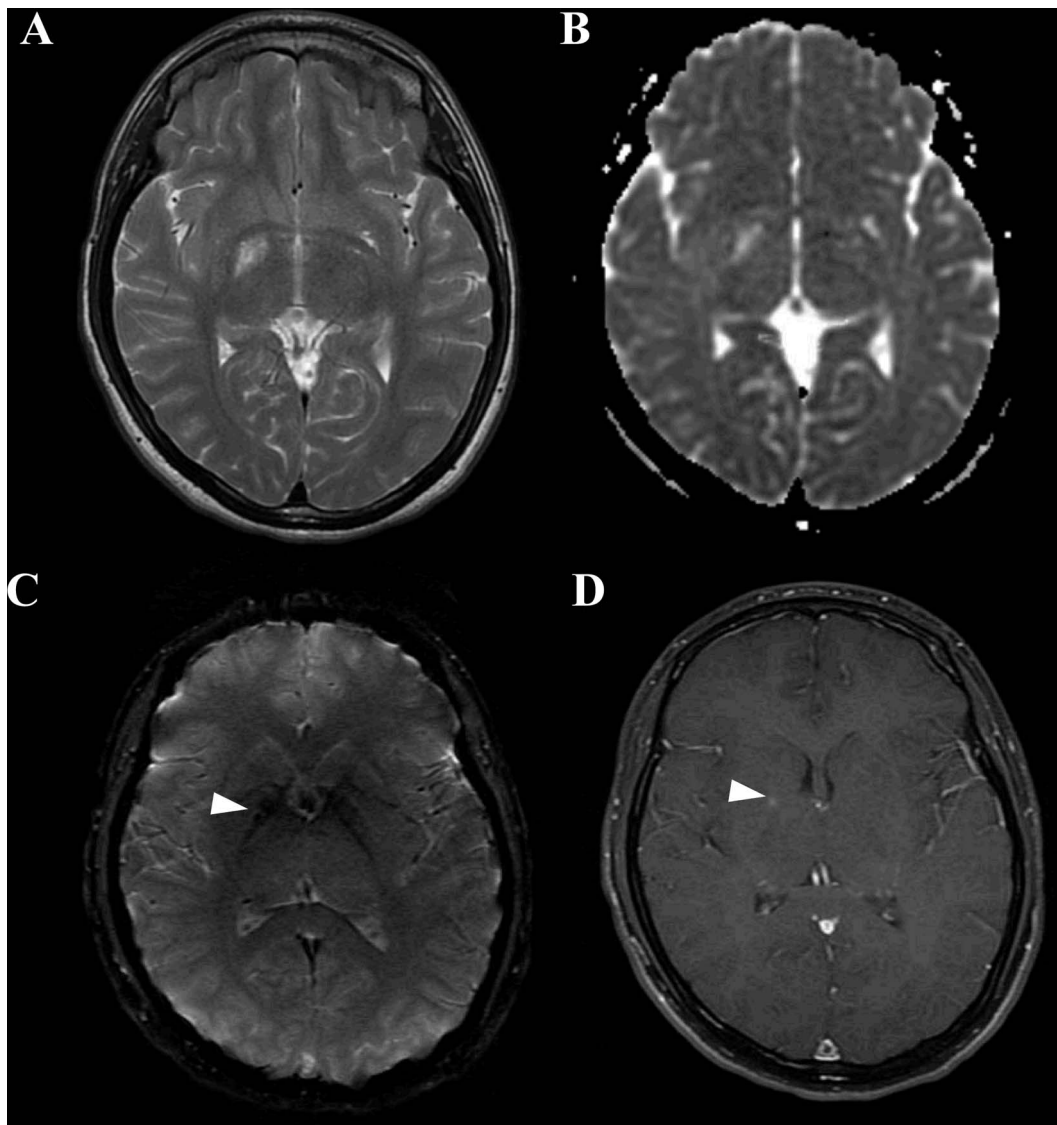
MRI features of right-sided lentiform nuclei haemorrhagic changes on T2 (A), apparent diffusion coefficient (B), susceptibility-weighted imaging (C) and postgadolinium (D) sequences consistent with a subacute haemorrhage.
